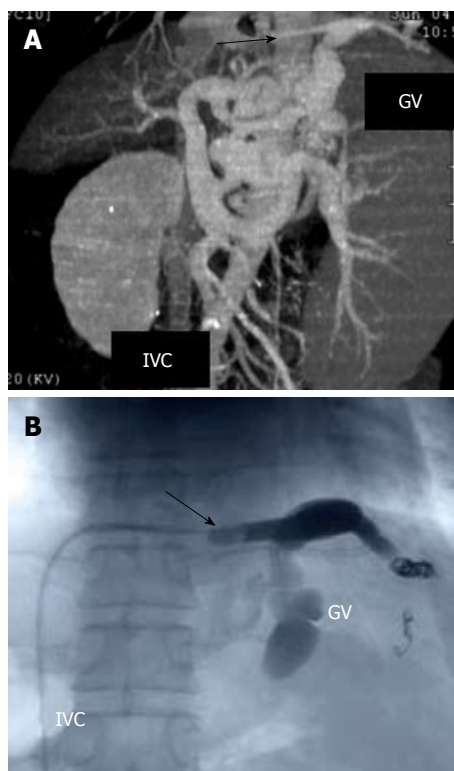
Multidimensional computed tomography (MDCT) revealing the varices supplied by the left gastric vein and drained into the subphrenic vein (arrow) which is connected to the inferior vena cava (IVC) (A), and fluoroscopic image of BRTO showing placement of the occlusive balloon catheter in the subphrenic vein (arrow) (B). After the blood vessels from the GV except for the main drainage vein were blocked with coils, 5% solution of ethanolamine oleate with iopamidol (EOI) was injected into the varices.
